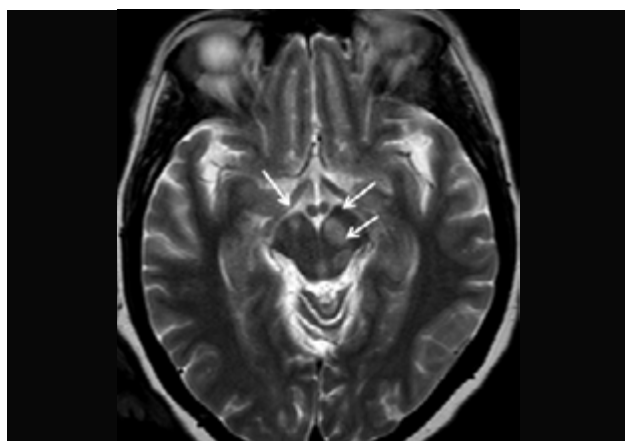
MRI of a 41-year-old man presenting with bilateral paresis. Axial T2WI sequence showing hyperintense lesions in the midbrain (arrows) in a patient subsequently diagnosed with neurotoxoplasmosis.
